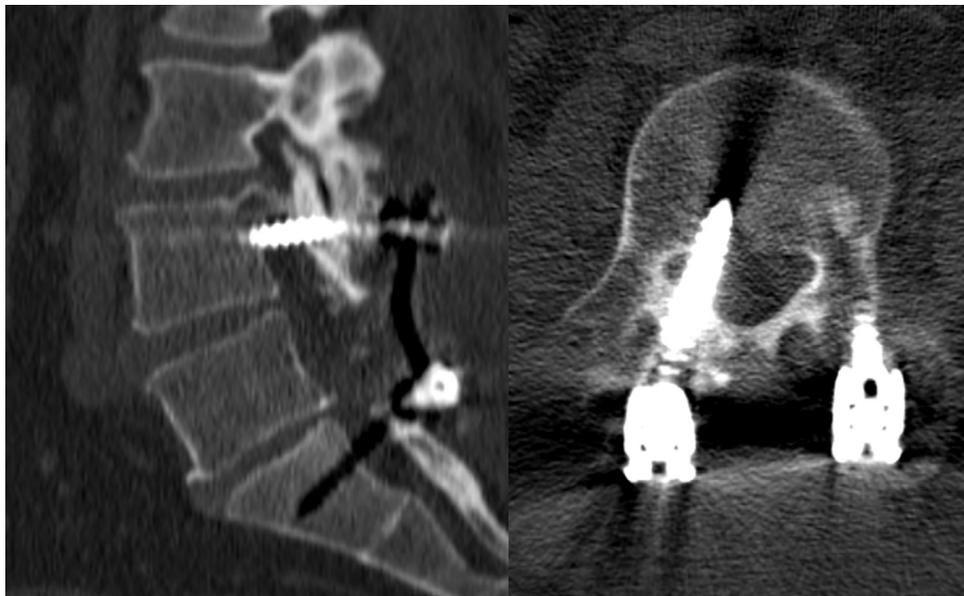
Malpositioned screw causing radiculopathy. Patient had worsening right L4 radiculopathy following an L4-S1 fusion with no pain-free interval. CT scan was obtained and showed malpositioned right L4 pedicle screw through the lateral aspect of the central canal.
